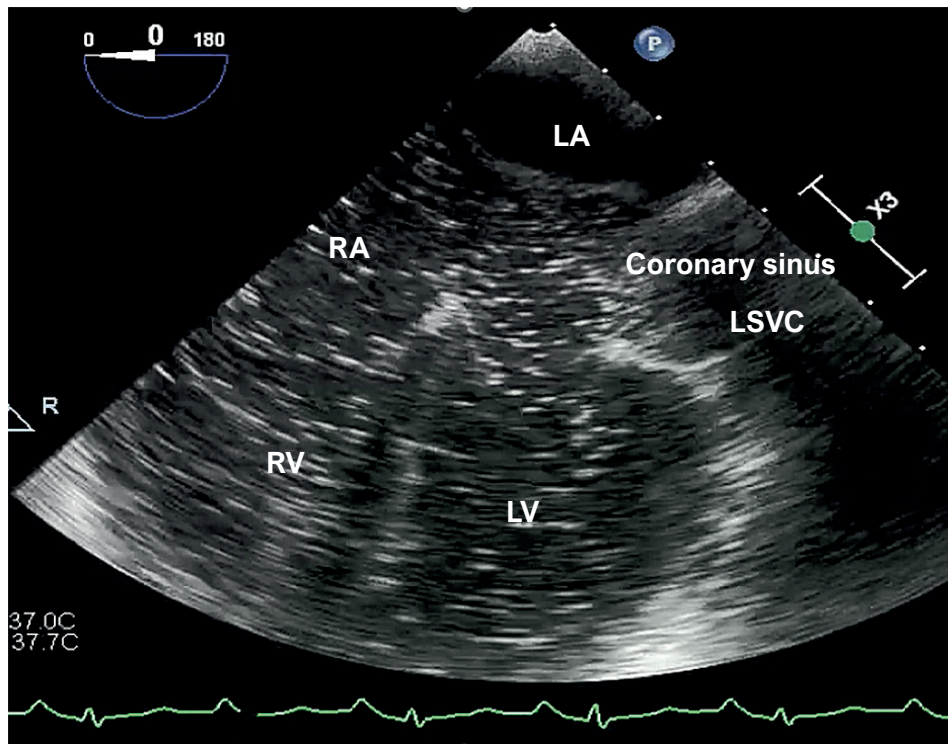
Transesophageal echocardiography in the four-chamber view after infusion of agitated saline contrast via peripheral IV access in the left upper limb, demonstrating opacification of the coronary sinus, the LSVC, and the LV, secondary to the presence of a coronary sinus-type ASD. ASD: atrial septal defect; LA: left atrium; LSVC: left superior vena cava; LV: left ventricle; RA: right atrium; RV: right ventricle.
